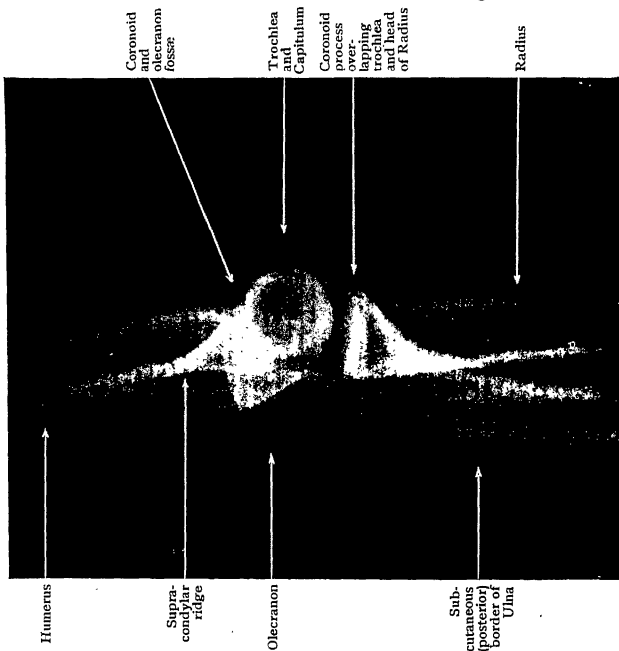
Lateral Radiograph of same Elbow as in Fig. 82 fully extended. Note the tip of the olecranon in the olecranon fossa of the Humerus.
